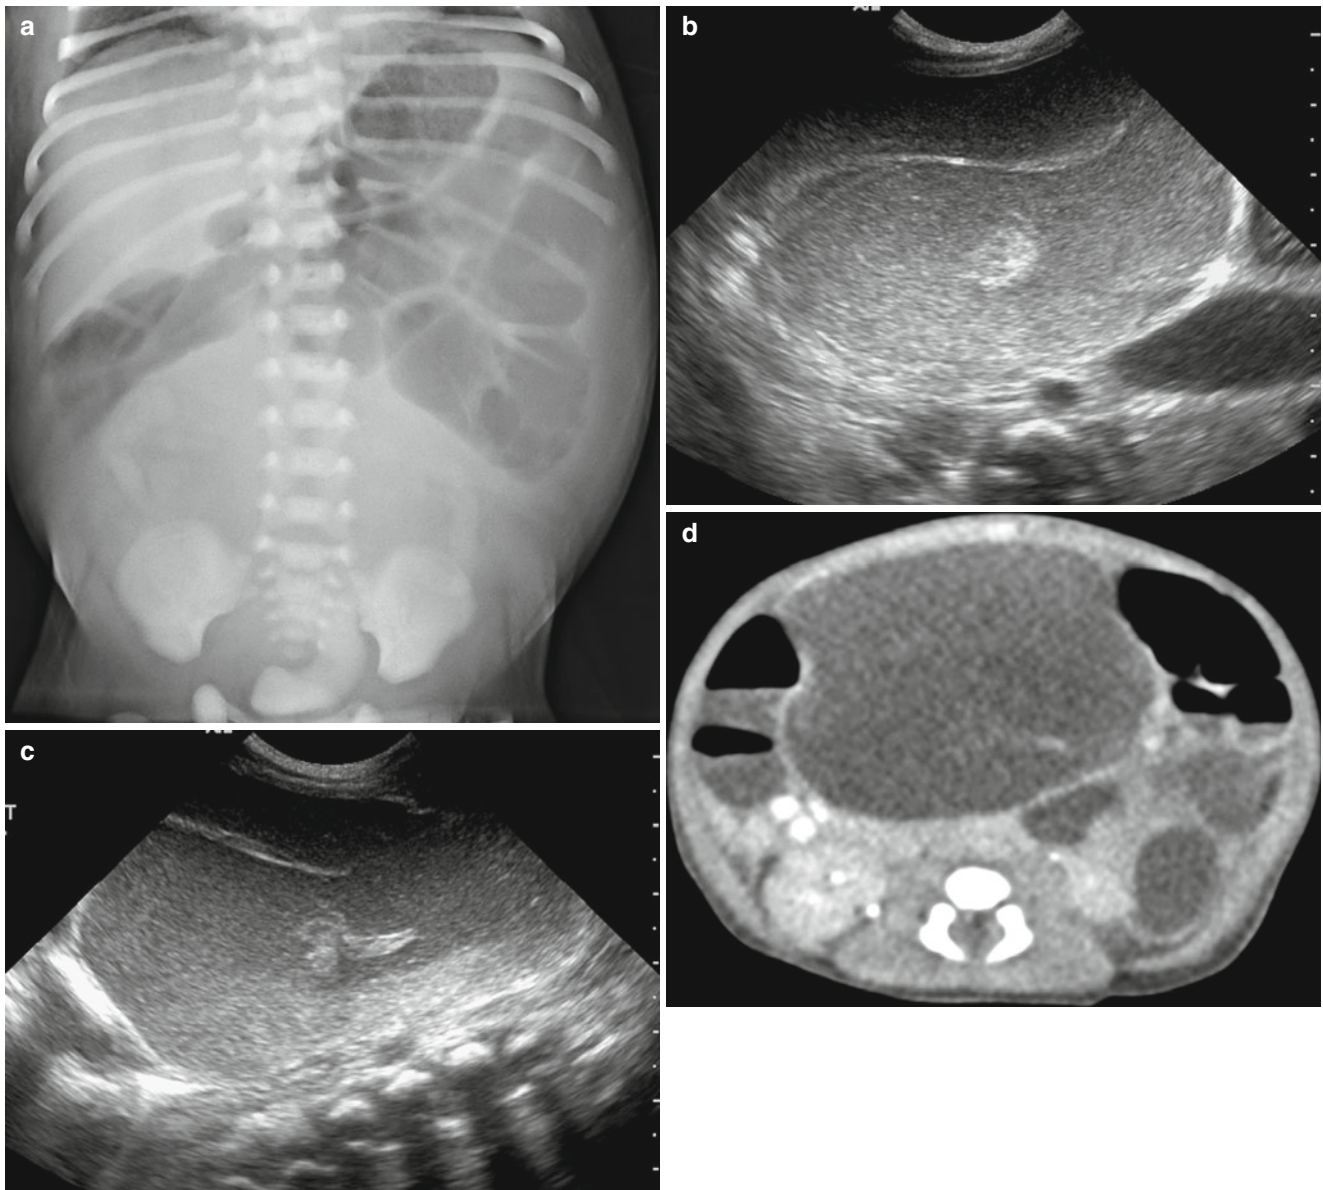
Jejunal atresia with meconium pseudocyst in a 1-day-old neonate with prenatal US diagnosis of abdominal mass. (a)* Abdominal radiograph demonstrates a soft tissue density mass lesion in the lower abdomen and several dilated small bowel loops. Transverse (b) and longitudinal (c) US at the midabdomen show a well-demarcated cystic
